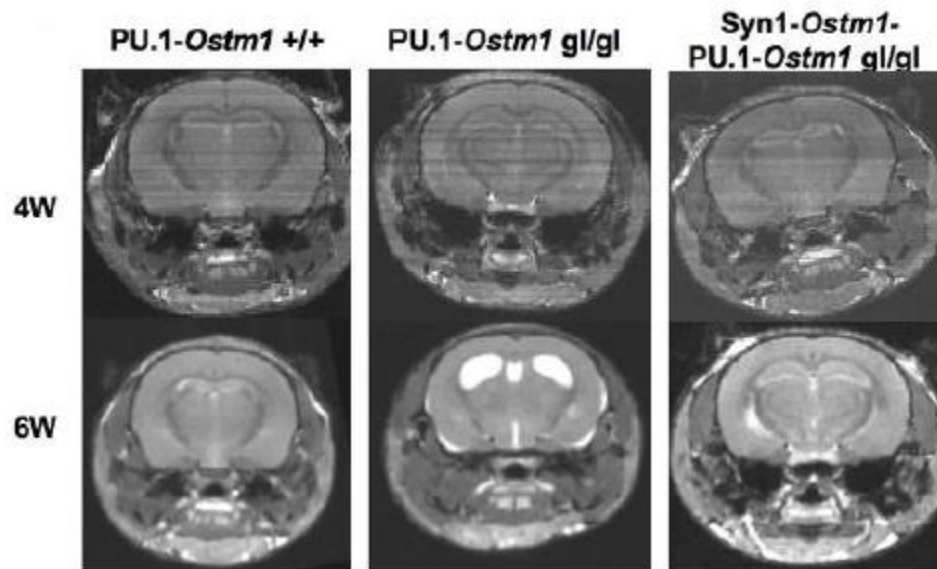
SYN1-*Ostm1* Transgene Rescued the Cerebral Atrophy and CNS Degeneration. MRI scan of 4-week-old and 6-week-old PU.1-*Ostm1* +/+, PU.1-*Ostm1* gl/gl, and PU.1-*Ostm1*-SYN1-*Ostm1* gl/gl brain. PU.1-*Ostm1*-SYN1-*Ostm1* gl/gl exhibited full brain size and morphology as in PU.1-*Ostm1* +/+ (Reprinted free access from the Journal of Biological Chemistry, Héraud, Griffiths et al. (2014)).
